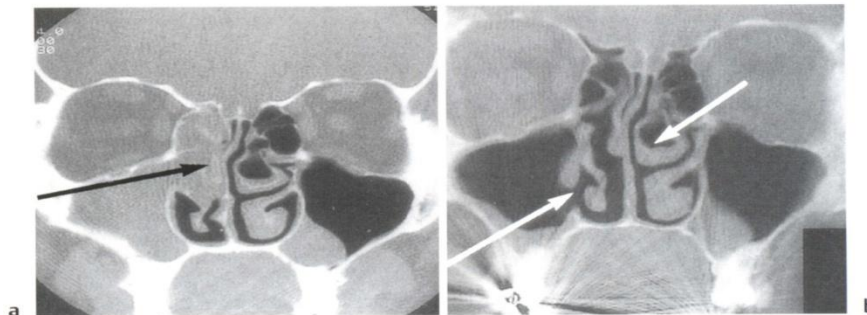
CT scans to show the sinuses. CT scans give a much more detailed picture of the maxillary, ethmoid, frontal, and sphenoid sinuses. They are routine when endoscopic sinus surgery is anticipated, and are also of additional help to the plain sinus radiograph for diagnosis. CT scans, however, involve considerably more radiation to the orbit and are expensive. Opacity of the ethmoid sinuses characteristic of infection is seen (a, arrow). Also seen is an air cell in the middle turbinate (concha bullosa; b, upper arrow) and a right intranasal antrostomy into the maxillary sinus (b, lower arrow).
